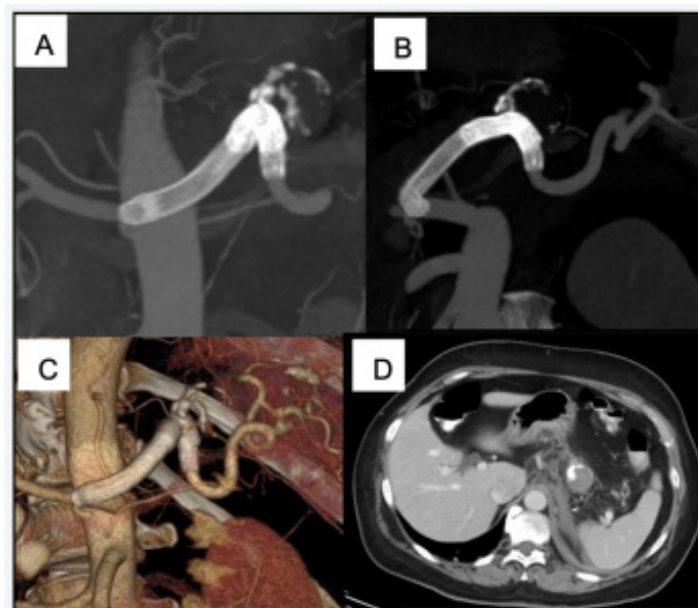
CT angiography at 6-month follow-up: MIP (A) and 3D (B, C) reconstructions show complete exclusion of the aneurysm, patency of the splenic artery, and correct location of stent-grafts. Axial CT image (D) evidence normal splenic parenchyma in the venous phase, without signs of complications.
